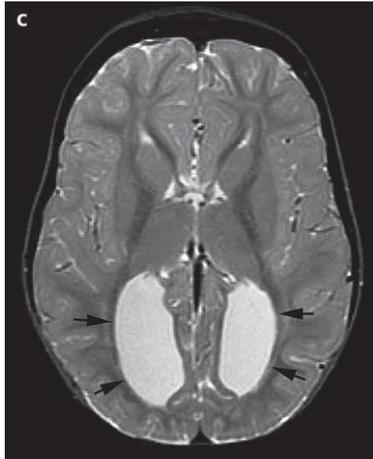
T2-weighted image on the axial plane showing the enlargement of the occipital horns of the lateral ventricles (colpocephaly). Barkovich A.J., Raybaud C. (2012) Pediatric neuroimaging. 5. Ed
